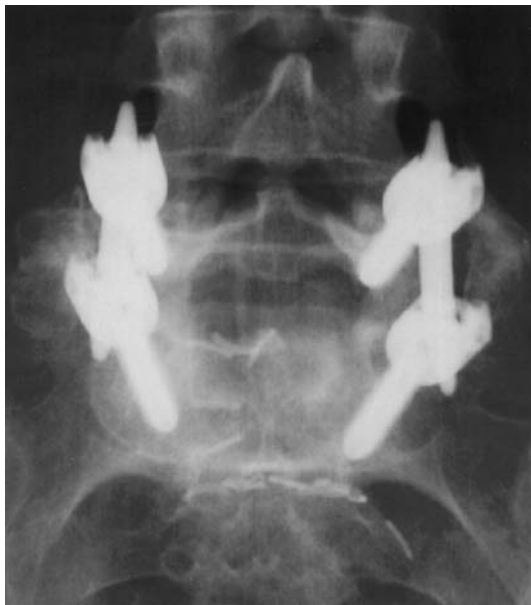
Anteroposterior radiograph demonstrating acceptable screw placement and bilateral posterolateral fusion.
